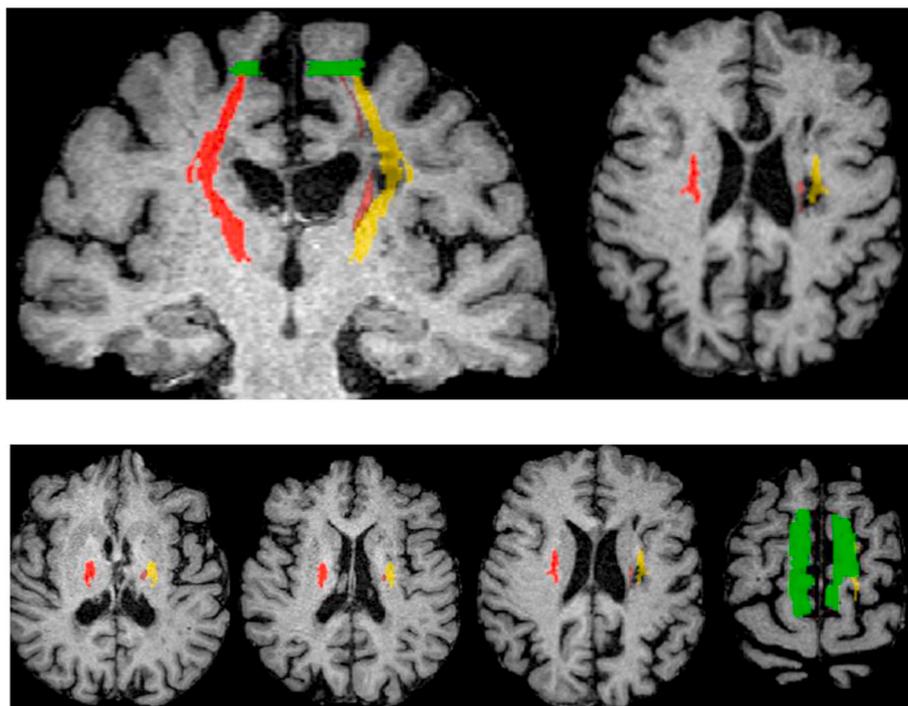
Top panel: Thalamic projections to the superior frontal gyrus in both hemispheres (red) shown on T1-weighted. Bottom panel: The same projections shown on axial slices from ventral (left) to dorsal (right). The superior frontal gyrus target masks are shown in green. The thalamus seed masks are shown in Figure A1. An estimate of destroyed white matter tissue (yellow) was achieved by reflecting the thresholded (10%) and binarized streamline connecting the thalamus to the SFG from the intact left hemisphere (in red) to the right hemisphere; and then subtracting the thresholded and binarized streamline between thalamus and the SFG in the damaged right hemisphere.
